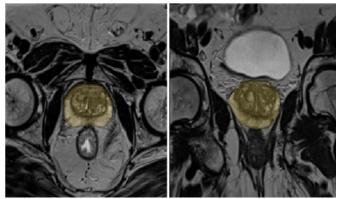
Prostate volume was calculate from axial and coronal MR images
